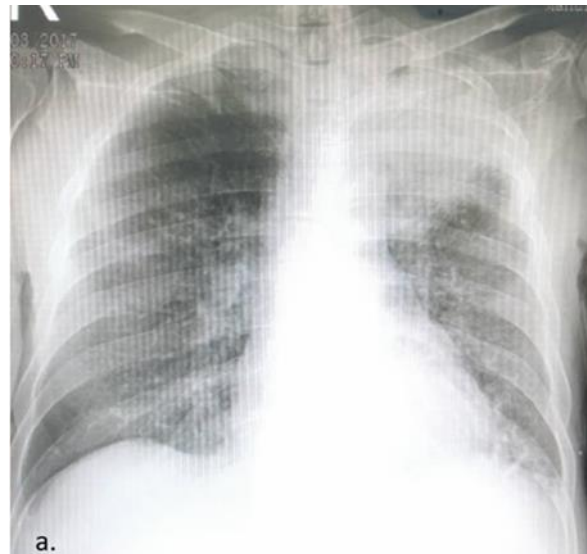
Chest radiograph performed in the emergency department.
